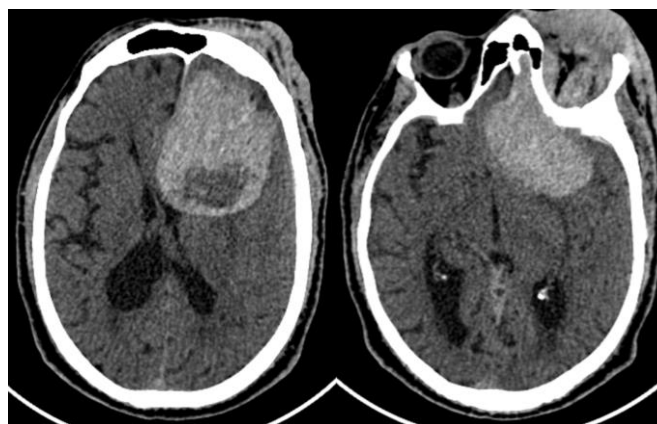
Computed tomography (CT): show spontaneously hyperdense extra axial process with central zone hypodense. Extending to the left orbit
